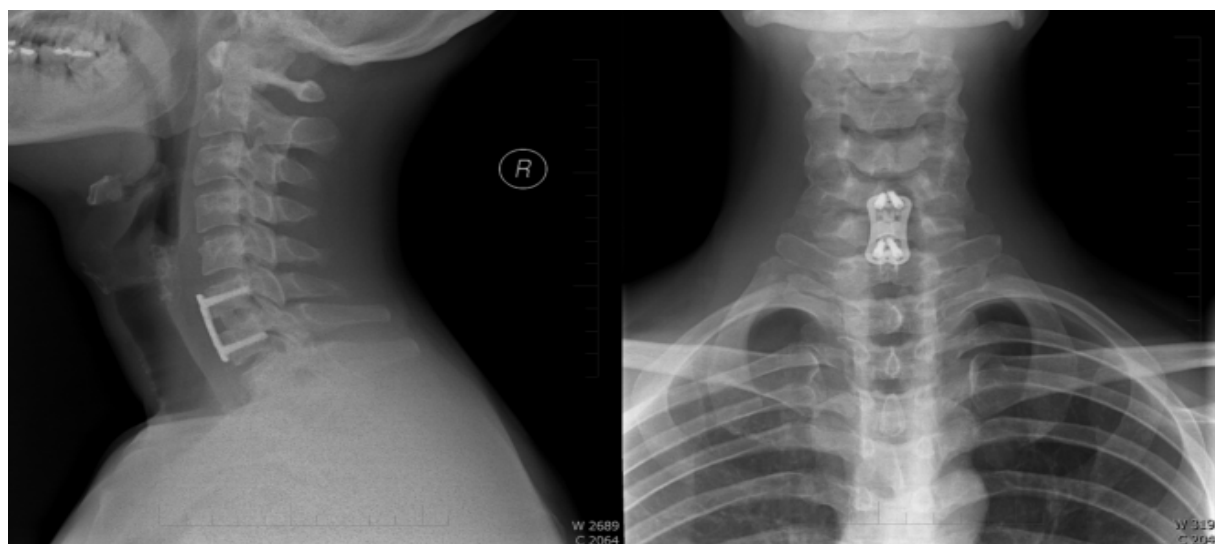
X-ray image 6 months after the surgery on C6/7 –PEEK/BCP (2011)
